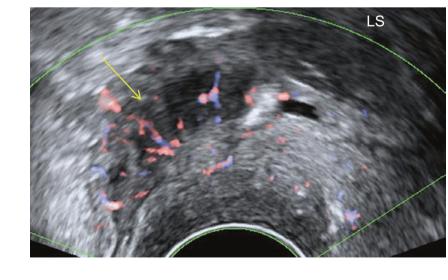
DIE lesion (*arrow*) showing poor vascularity on Doppler
